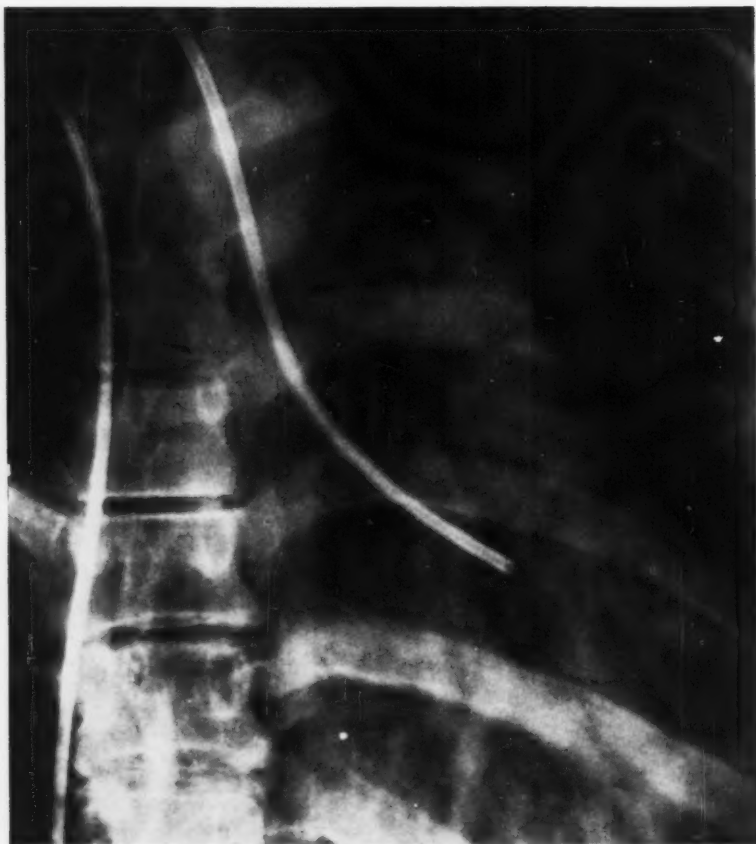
Spot x-ray film during retrograde aortic catheterization showing aortic catheter traversing fistula from right sinus of Valsalva into right ventricle.
